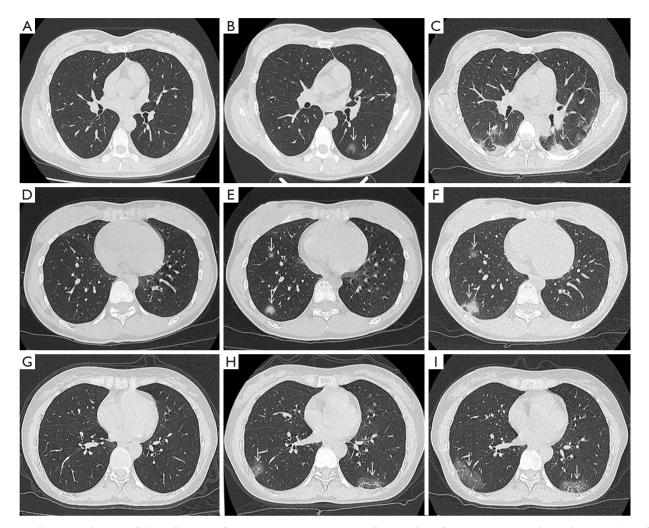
Dynamic changes of chest CT scans from 3 symptomatic patients. Case 1: chest CT scan was normal on admission (A). After two days, it showed multiple ground-glass opacities in left lung (B, arrows). A chest CT scan performed one week later showed further progression of pneumonia with bilateral lung exudations (C, arrows). Case 2: chest CT scan was normal on admission (D). A follow-up chest CT scan performed three days later revealed multiple ground-glass opacities in right lung (E, arrows). Continued progression of lung lesions was observed four days later (F, arrows). Case 3: chest CT scan was normal on admission (G). A follow-up chest CT scan performed three days later revealed multiple ground-glass opacities in peripheral of two lower lungs (H, arrows). Enlargement of the area of ground-glass opacities was shown on a chest CT scan after 3 days (I, arrows).
